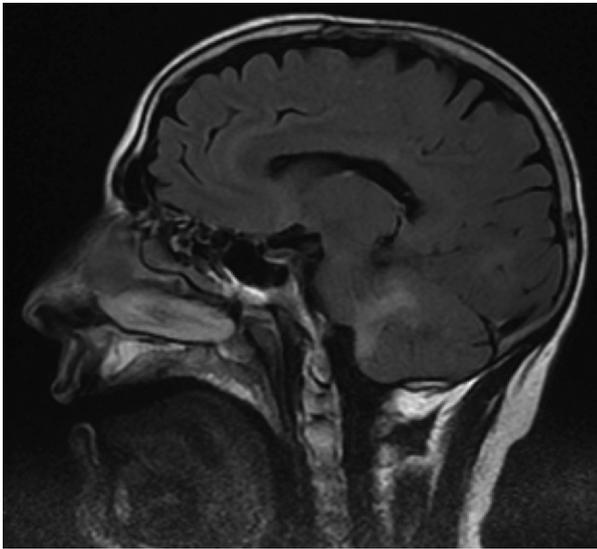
T1-weighted brain MRI. Lesion suggesting inflammation of the cerebellar peduncles.
